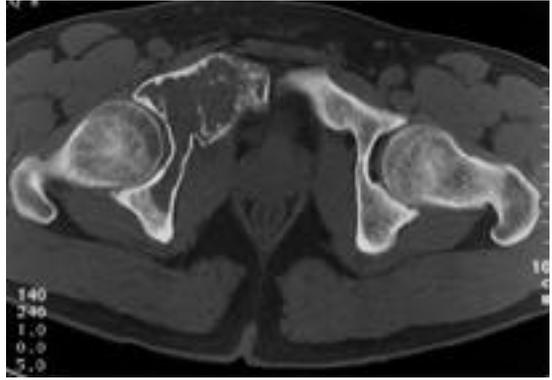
CT shows low density lesion with periosteal reaction of continuous type. The matrix of the lesion shows lower density than the adjacent muscles.
